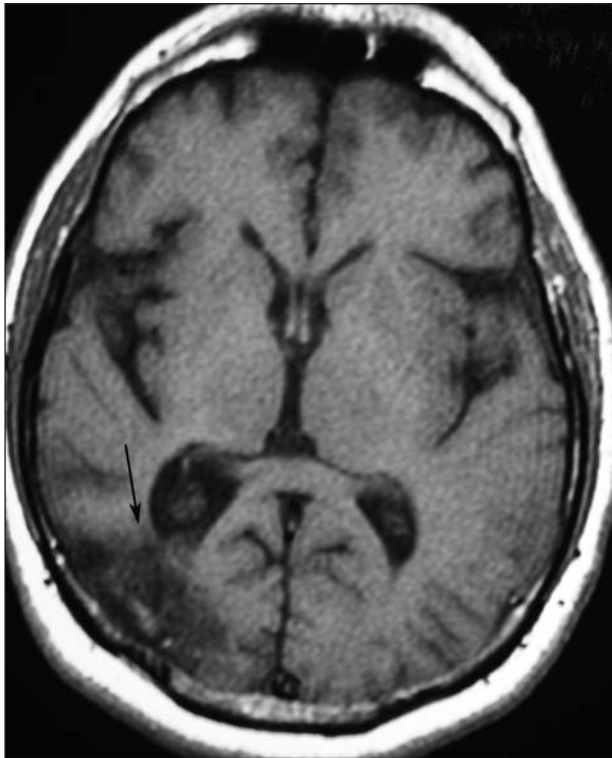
Axial MRI view showing an area suggestive of a previous ischemia in the right parieto-occipital region (arrow) and signs of brain atrophy.
